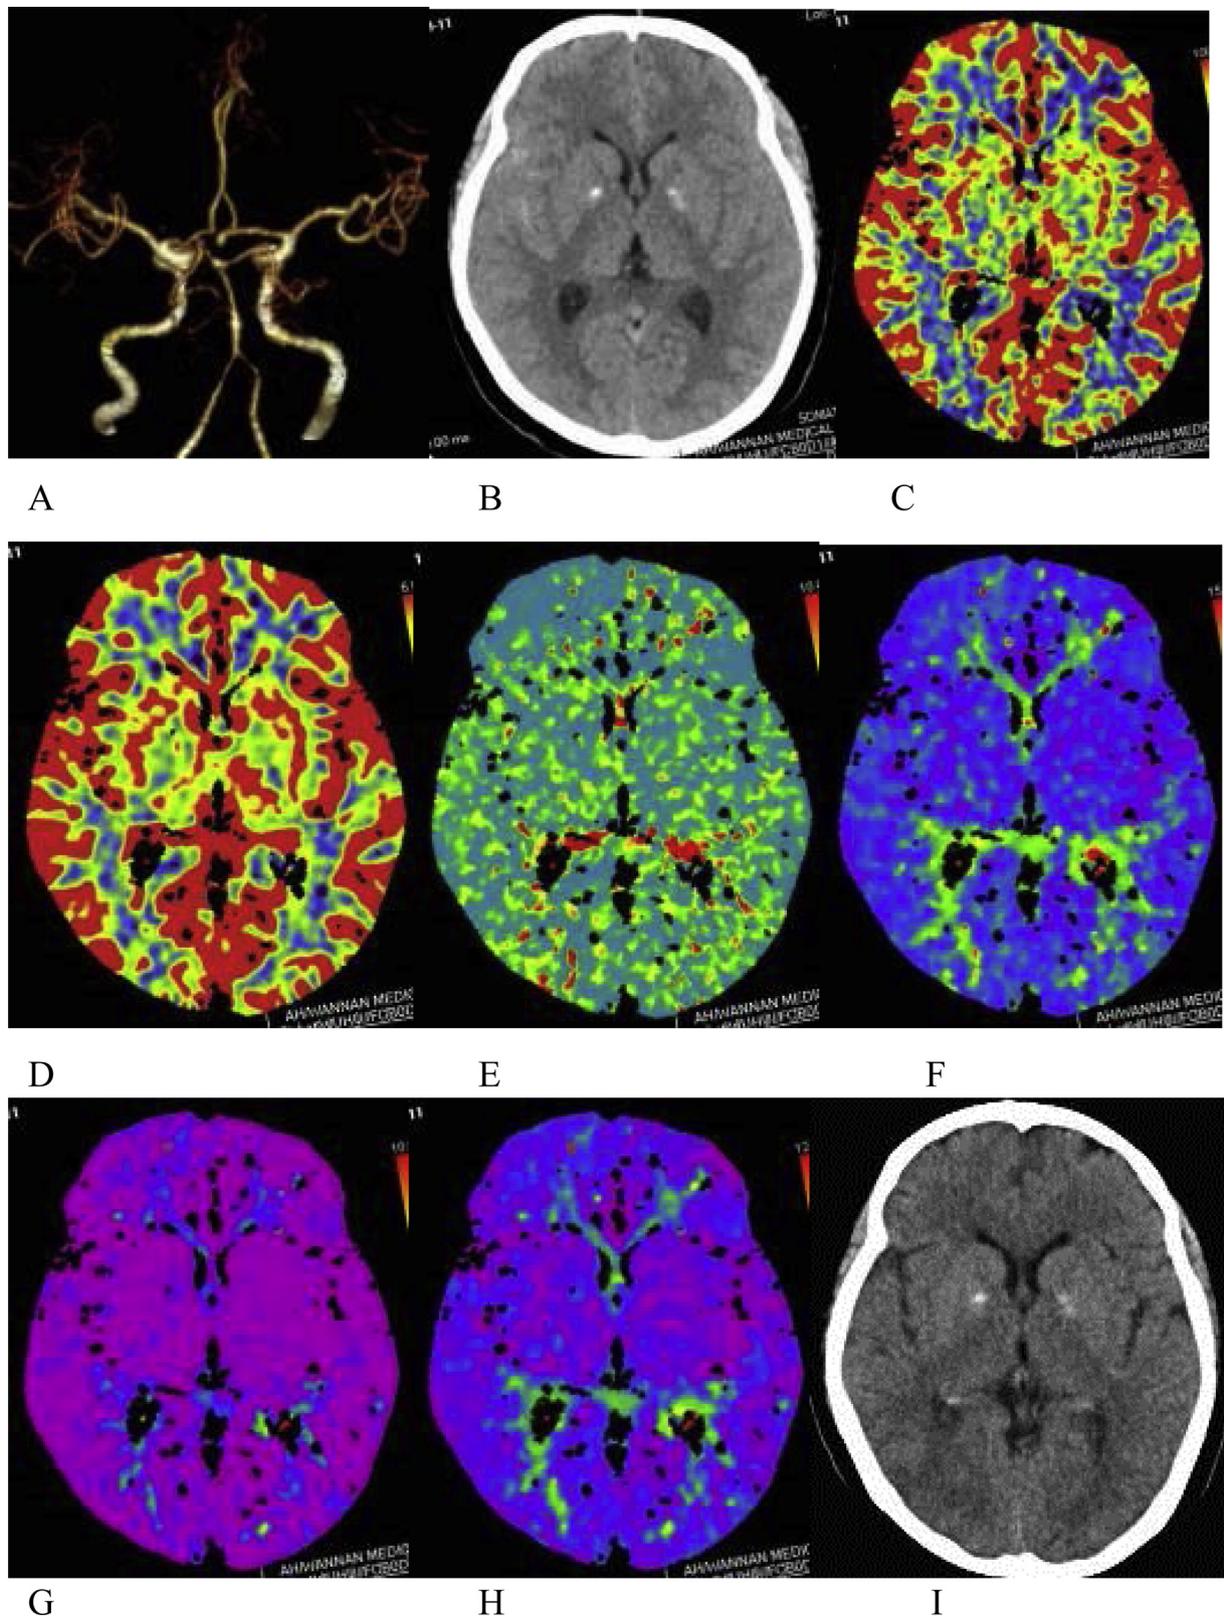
A 52-year-old female patient with ruptured anterior communicating aneurysm on admission and without DCI. CTA (A) showed anterior communicating aneurysm. The Fisher score was 2 on NCCT (B). Color-coded maps of CTP parameters including CBF (C), CBV (D), MTT (E), TTD (F), TTS (G), and TMax (H) revealed no perfusion abnormalities. There were no signs or symptoms of DCI on follow-up CT (I).
